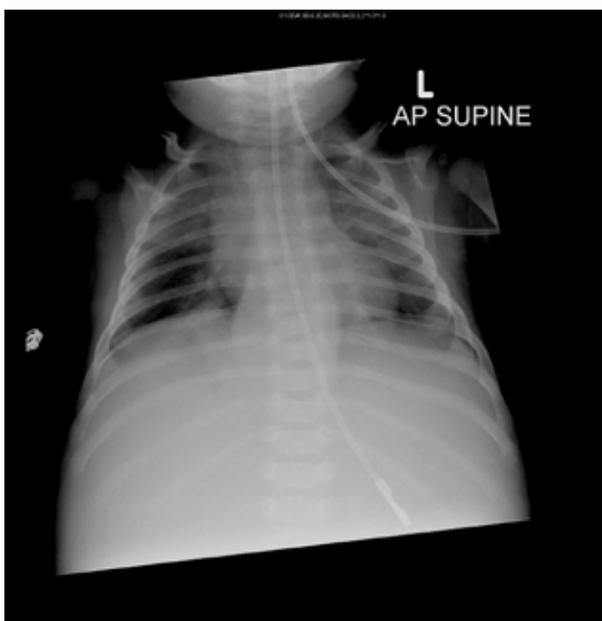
Chest radiograph showing posterior mediastinal mass.
